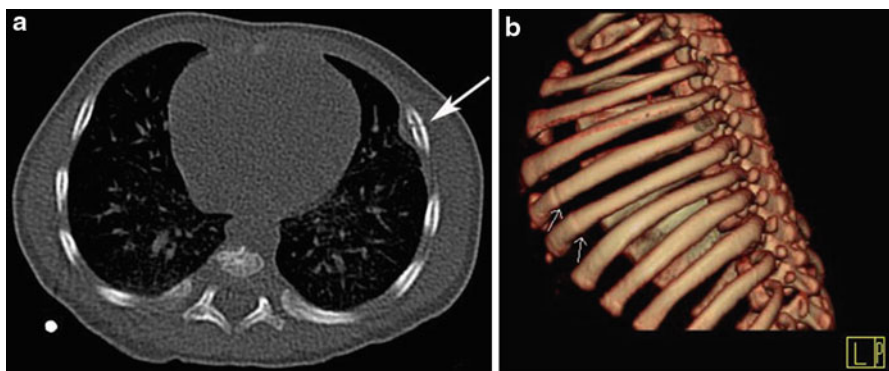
Axial CT chest image in a 2-month-old male in bone window (a) and 3D reconstructed CT image (b) show nondisplaced acute fractures in left anterolateral portion (*arrows*)
